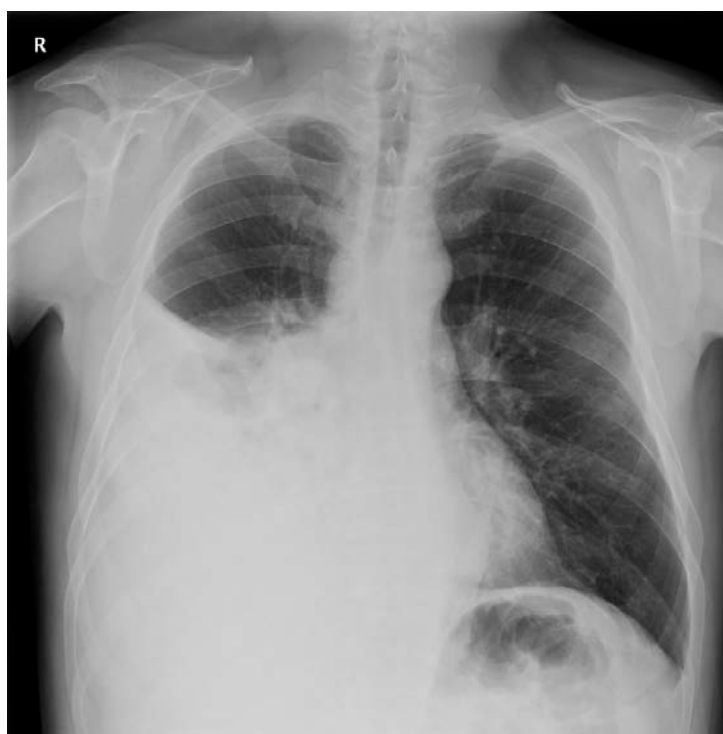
Initial chest radiography
